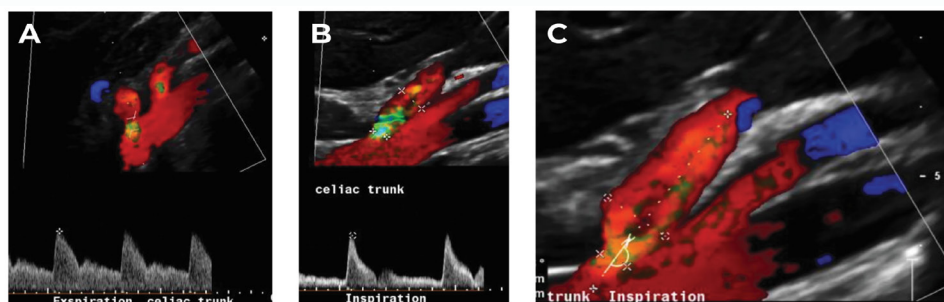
Ultrasound of celiac artery. (A) Expiratory phase US celiac artery-angulation at the celiac trunk. Turbulence of flow is visible with elevated flow velocity. (B, C) Inspiratory phase US celiac artery, even in deep inspiration, with retraction of the median arcuate ligament, there is compression of the origin of the celiac trunk, with a sagittal diameter of 4 mm, and 10 mm more distally. Flow turbulence is visible at the compressed origin, though angulation of the celiac trunk disappears.
